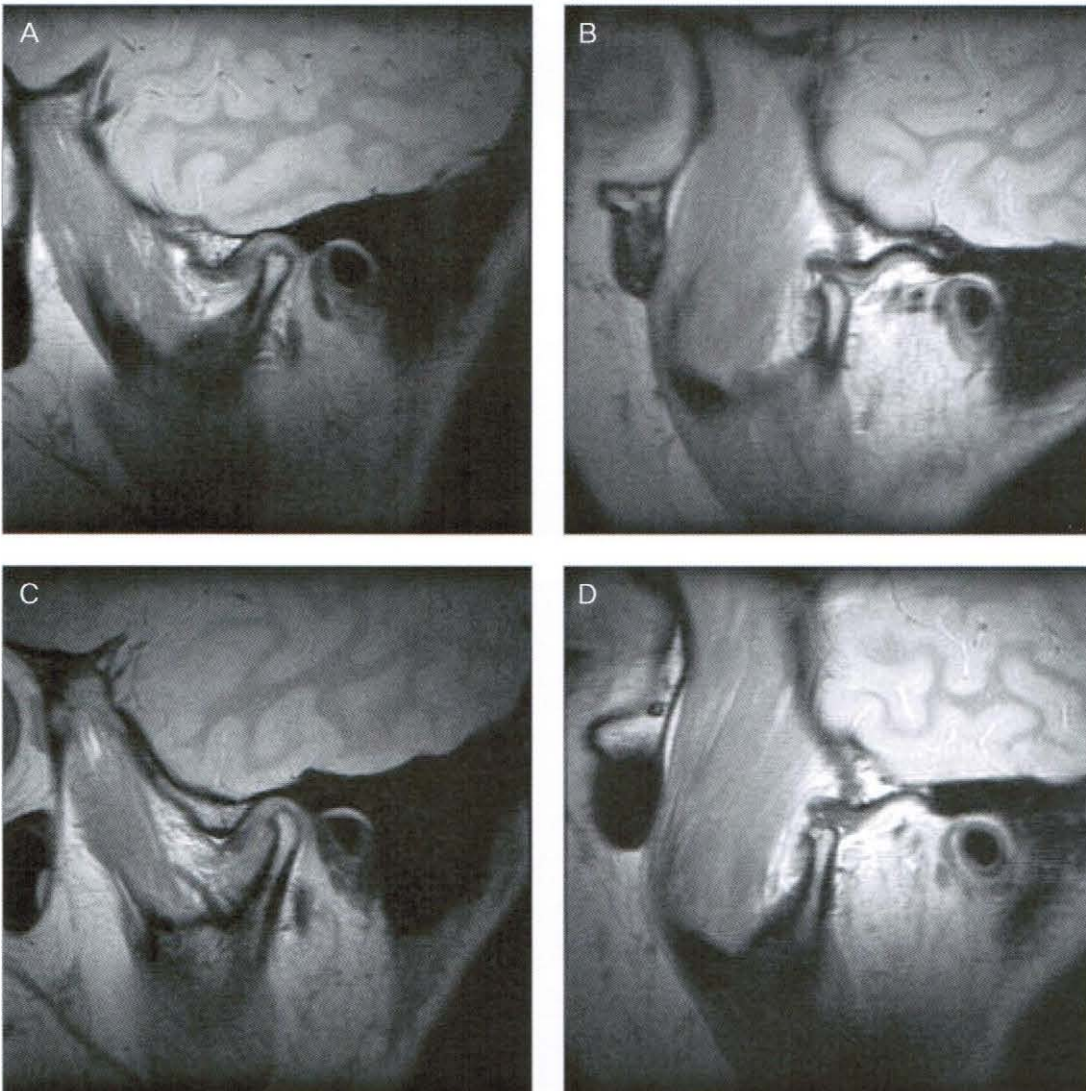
MRI (2005, 4,22)
